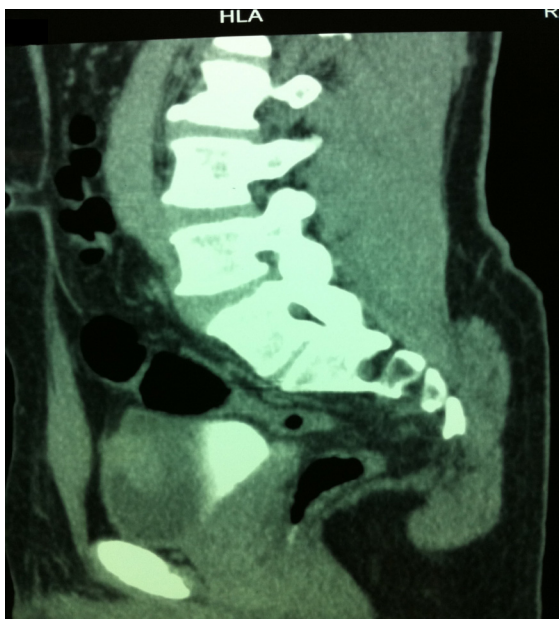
CT scan of the pelvis coronal view showing urachal tumor.
